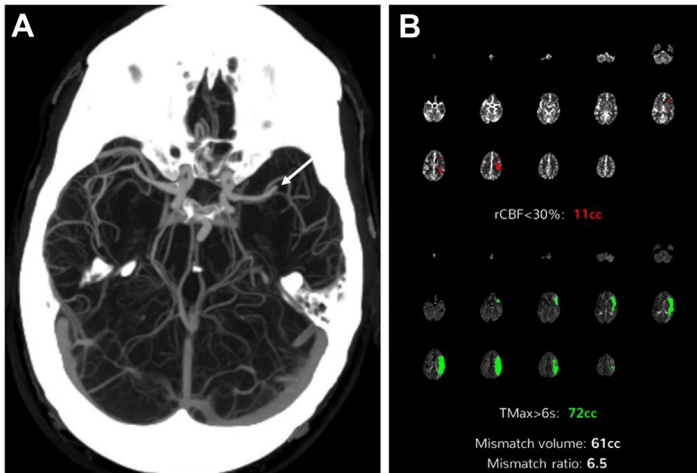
Case presentation: A 31-year-old male with a prior left hemispheric stroke and alcohol use disorder presented to the emergency department 7 hours from last known well after he awoke with aphasia and right-sided hemiparesis. NIHSS was 15. CT angiogram of the head and neck showed an occlusion of the left middle cerebral artery at the M2 segment (A). CT perfusion showed a large perfusion deficit (B). Patient's imaging was felt to be favorable, given the core size of 11 cc was less than 70 cc, the mismatch ratio at 6.5 was above 1.8, and the mismatch volume at 61 cc was above 15 cc, meeting the radiographic parameters of the DEFUSE 3 trial. Consequently, the patient was taken for mechanical thrombectomy in the extended time window. A TIC1 3 revascularization was achieved. Patient's NIHSS at 90 days was 1 for aphasia with an mRS of 1. The arrow is pointing to the occluded left middle cerebral artery.
